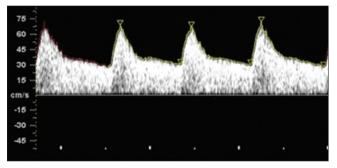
Normal uterine artery Doppler waves in the first trimester [9]
